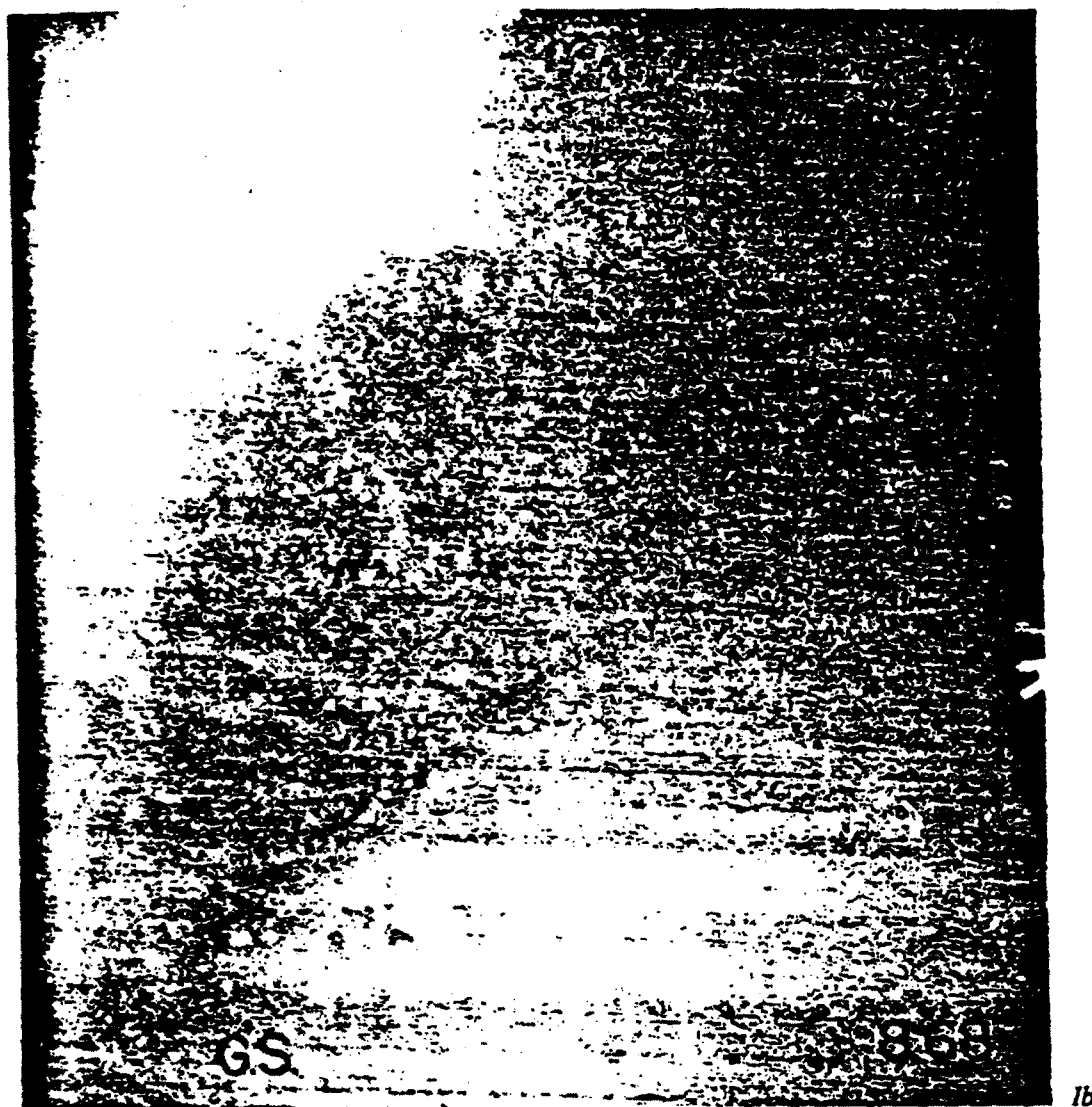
The postero-anterior chest roentgenogram (A) shows small lungs with only 8 posterior ribs visible. There is a dense linear infiltrate which is more marked in the lower zone. The outlines of the heart and diaphragm are ill-defined and there is diffuse pleural thickening. The lateral film (B) emphasizes the high diaphragm, basal infiltration and perhaps a pleural plaque anteriorly.
